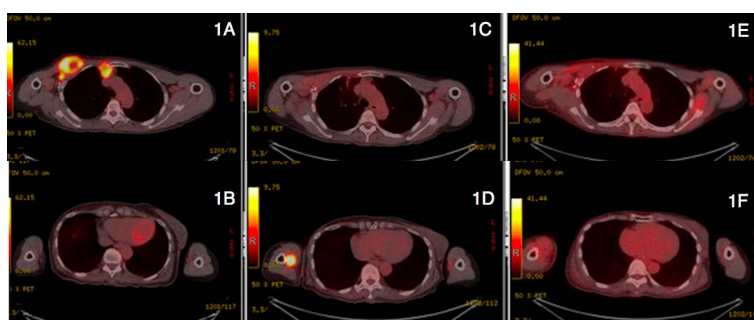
Axial views of the patient's PET/CT imaging before the first course of IMPT in March 2015 (1A & 1B), before the second course of IMPT in September 2015 (1C & 1D), and at most recent follow up in August 2018 (1E & 1F). PET: positron emission tomography. CT: computed tomography. IMPT: intensity modulated proton therapy.
